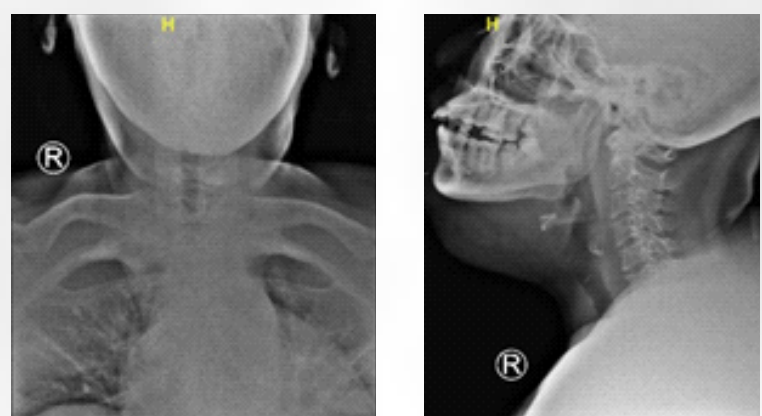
Neck soft tissue radiograph
